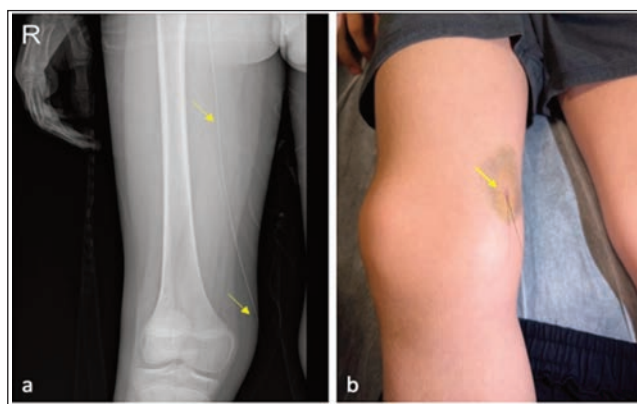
Radiograph and photograph of the patient. (a) Radiograph of the femur showing the wire extending outward at the level of the distal femoral vein near the knee. (b) photograph showing the foreign body, indicated by the yellow arrow, consistent with the guidewire.
